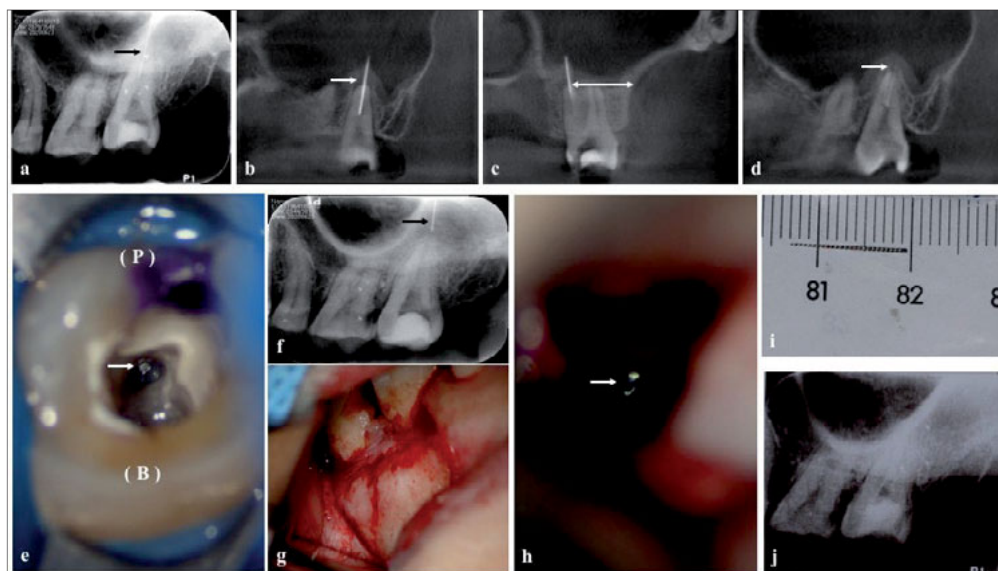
(a) A periapical radiograph revealed a fragment in the maxillary left second molar (black arrow). (b) Half of the fragment (approximately 6 mm) was extruded into the maxillary sinus (white arrow). (c) The distance between the root apex and the buccal cortex was 12.6 mm (white arrow). (d) Periapical periodontitis and fenestration of the maxillary floor could be observed (white arrow). (e) The fragment was located in the palatal canal (white arrow). (f) The fragment was extruded completely beyond the apex (black arrow). (g) The lateral wall of the maxillary sinus was
